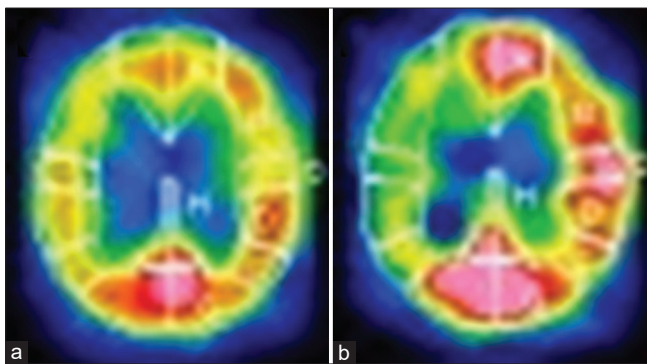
SPECT images at the age of 53 show a subtle decrease in CBF in the right compared to the left hemisphere at rest (a) and hemodynamic compromise after acetazolamide challenge (b).
